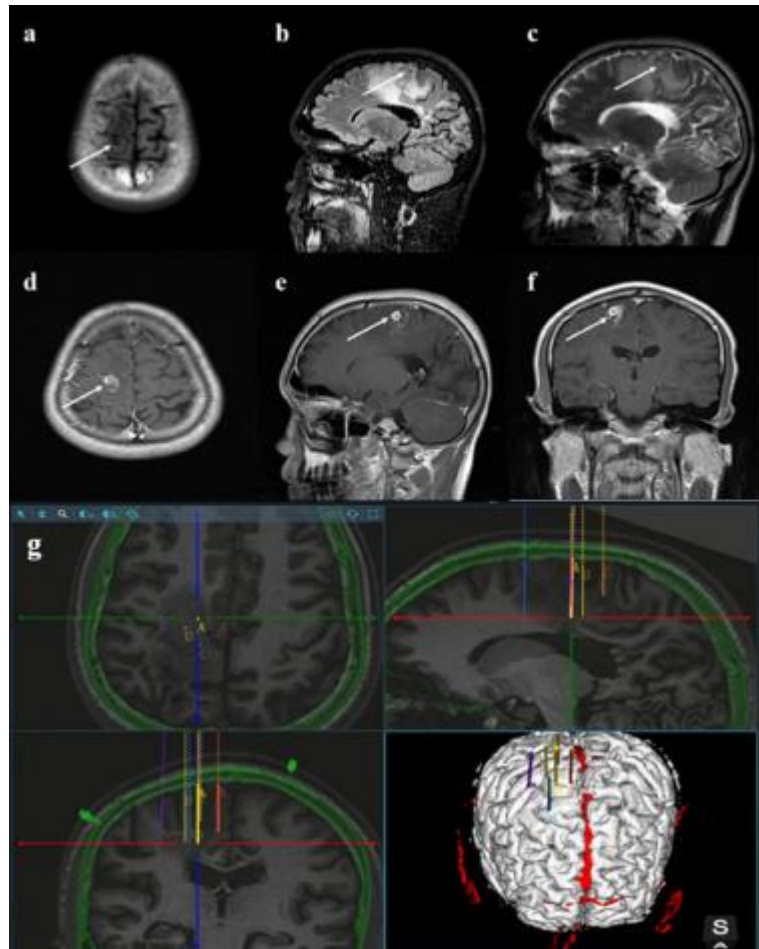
Axial (a), sagittal (b), and sagittal (c) T2-weighted preoperative magnetic resonance imaging scans. axial (d), sagittal (e), and coronal (f) preoperative T1-weighted MRI images enhanced with contrast are shown. To carry out the surgical plan for lesion biopsy and resection in functional areas, neurosurgery robot-assisted frameless stereotactic technology was utilized (g).
